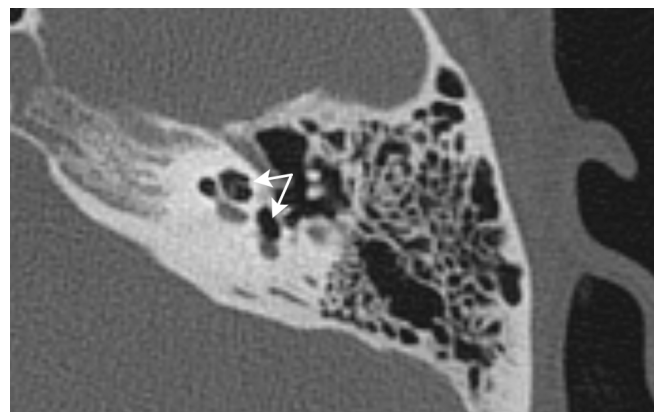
CT scan at admission, left temporal bone of patient K. aged 32; the arrows indicate the presence of air in the cochlea and vestibule
